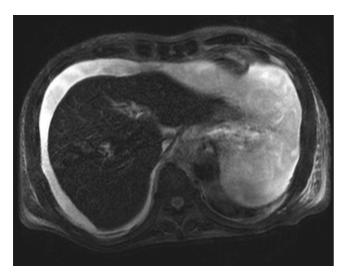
T2-weighted magnetic resonance images showed a large amount of ascites.
